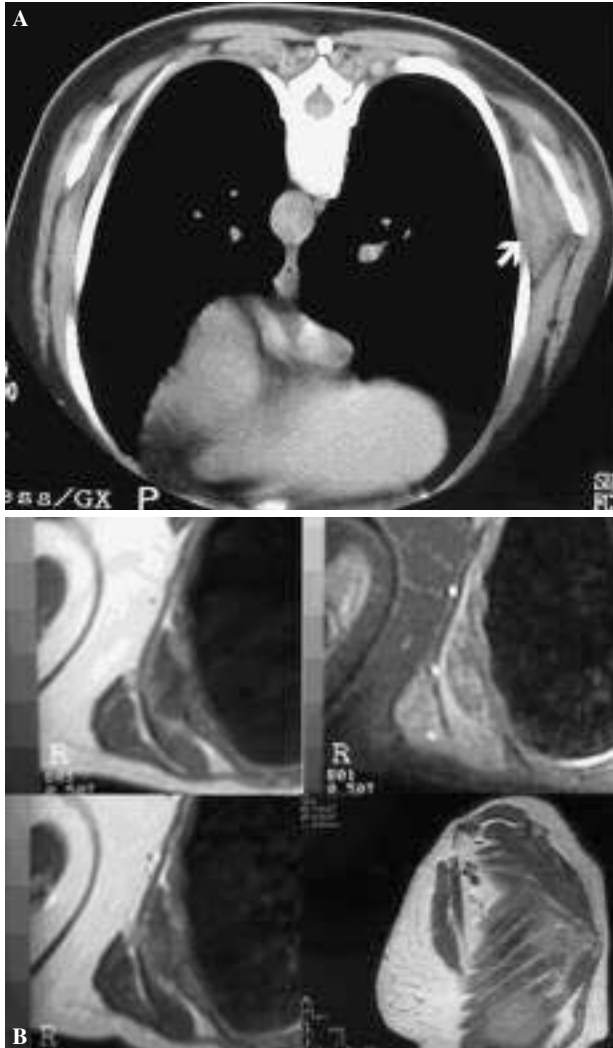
(A) Computerized Axial Tomography with no contrast medium enhancement of the subscapular region of our patient. Performed in the prone position in order to avoid soft tissue compression. The image shows an unencapsulated well-delimited lenticular-shaped thoracic wall mass (arrow) that displaces the serratus major muscle anteriorly and the lower scapular border laterally; the mass is characterized by lower attenuation than the muscles and higher attenuation than the subcutaneous fat. Note the small less dense linear areas within the mass that reveal the presence of fat. Although well defined by the fat laterally, the lesion cannot be separated from the intercostal muscles. (B) Magnetic Resonance sequences. a) T1-weighted echo spin sequence: a relatively well-defined mass can be seen of intensity similar to that of skeletal muscle, with intermingled high-intensity small curved areas; b) T2-weighted images: homogeneous relatively well-defined mass located between the thoracic wall and the scapular girdle that presents with intensity similar to skeletal muscle with intermingled high-intensity linear areas suggesting the presence of fat, whose distribution is similar to that of those in T1-weighted images; c) and d) T1-weighted axial and sagittal views showing a heterogeneous intensity increase following administration of gadolinium; a slight enhancement is seen mainly on the periphery.
